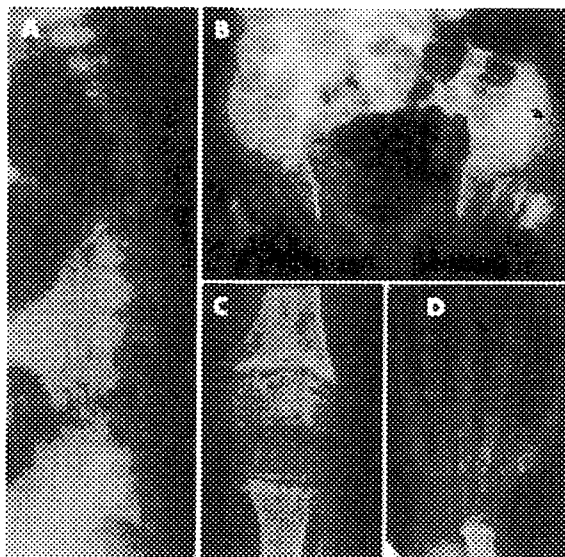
Radiographs of patient 1 at age 1 day: chest and abdomen (A), lateral spine (B), arm (C) and leg (D). Note the narrow thorax, short ribs with cupped anterior ends, severe dense platyspondyly, lacy iliac crests, delayed ossification of the caudal ilia, and metaphyseal cupping and irregularity of the tubular bones. The proximal femoral metaphysis has a faded area with a rounded end, similar to what is seen in spondylometaphyseal dysplasia Sedaghatian type.
